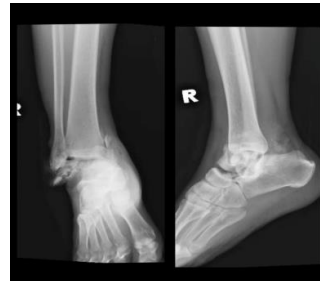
Post trauma x-ray
